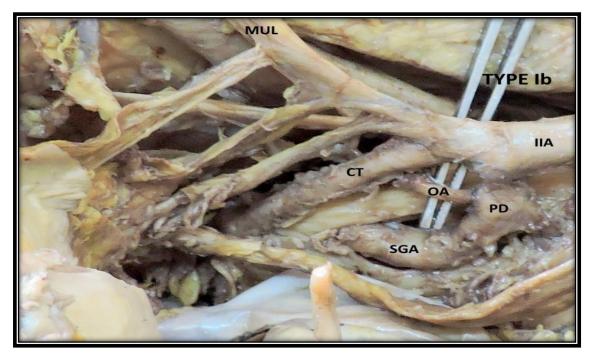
Right pelvic half shows type Ib Adachi's classification—Superior gluteal artery (SGA) arises separately from internal iliac artery (IIA) and a common trunk (CT) for Inferior gluteal artery (IGA) and Internal pudendal artery (IPA) divides outside the pelvis, below pelvic floor. OA: Obturator artery
